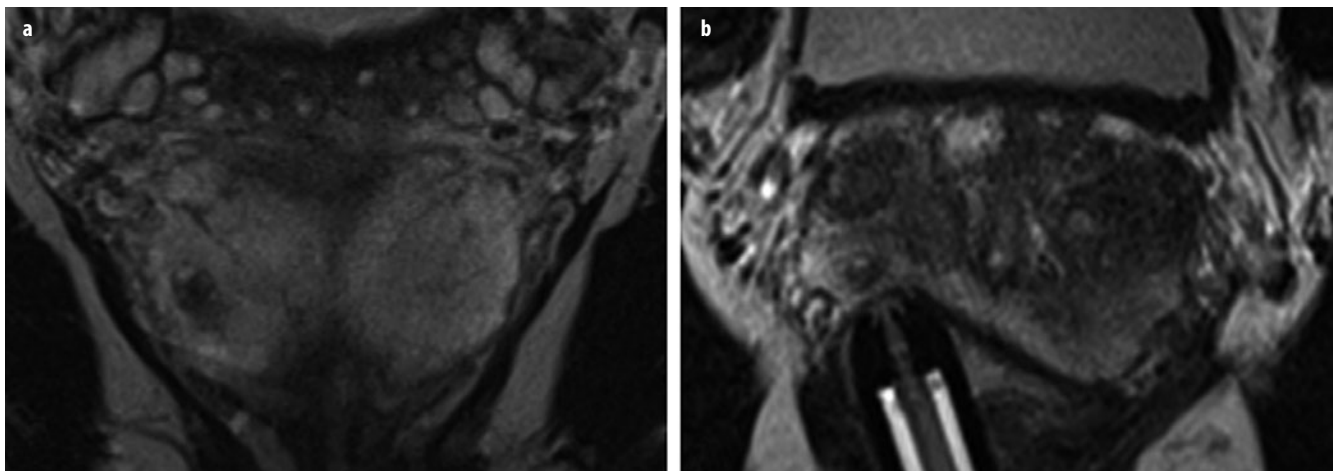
a, b. Patient with a negative ultrasound (US)-guided biopsy in history and increasing prostate-specific antigen (PSA) value; 12 ng/ml at the time of magnetic resonance imaging (MRI). a Coronal T2-weighted turbo-spin-echo (TSE) with lesion suspicious for cancer measuring a maximum of 5×7 mm in the peripheral zone. b Targeted biopsy under direct MRI guidance yielded a total sample length of 12 mm, with 4 mm of an acinar prostate adenocarcinoma (Gleason score $3 + 3 = 6$)
